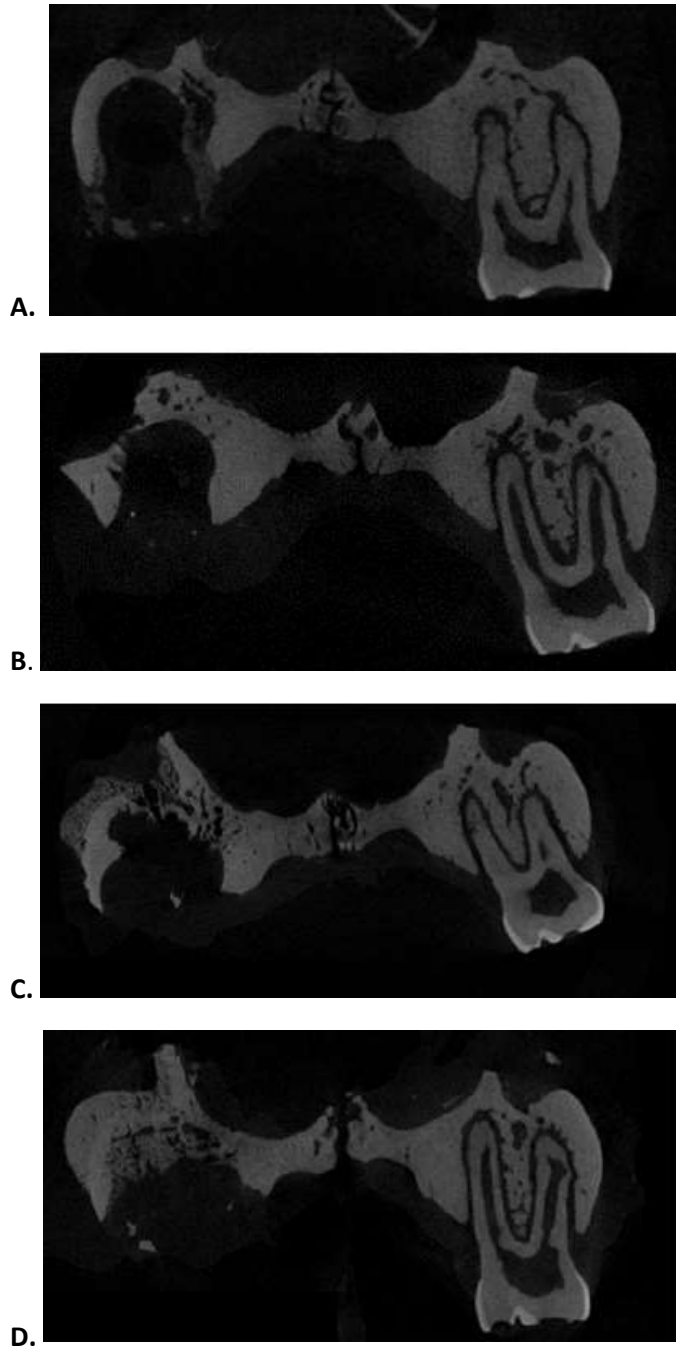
Representative μ CT for buccal and palatal bone loss from Part 1.
